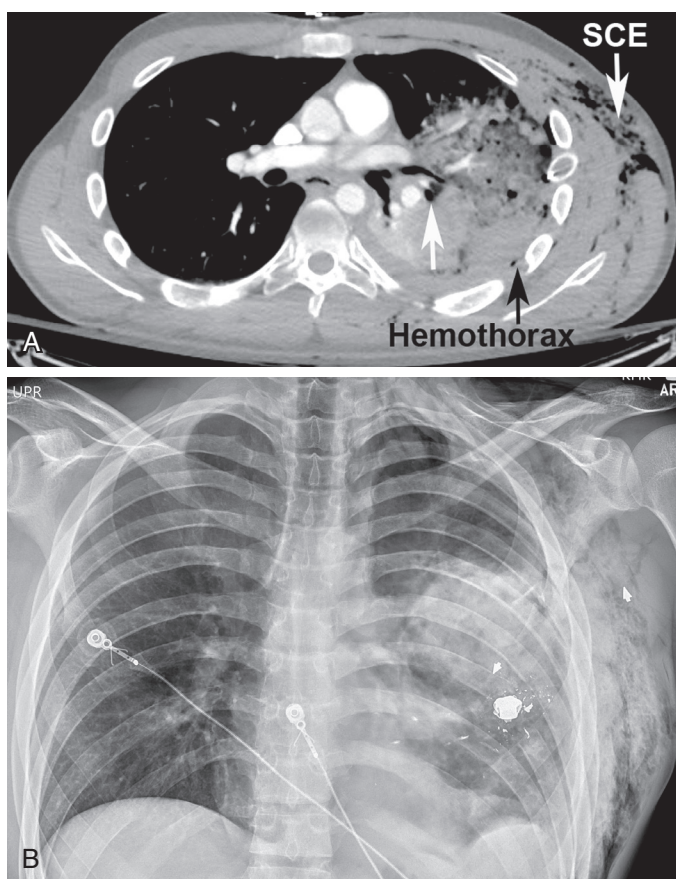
■ A, Axial computed tomography (CT) slice at level of hila. Left lower and upper lobe airspace opacities, consistent with a contusion. Associated parenchymal laceration (*white arrow*), hemo-pneumothorax, and subcutaneous emphysema (SCE), all sustained by trauma from a gunshot. B, Corresponding anteroposterior (AP) chest x-ray. Small arrow in left axilla is a marker placed on the patient's skin to indicate the bullet entry site.
